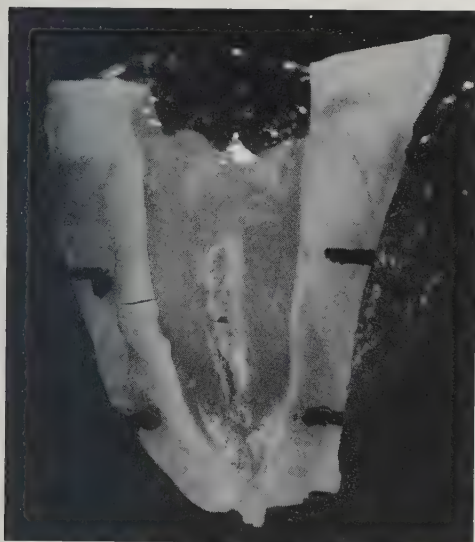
Experimental sequence, tooth 2; i) pre-operative (bucco-lingual radiograph); ii) mesial canals obturated (bucco-lingual radiograph); iii) after GPX (mesio-distal radiograph).
